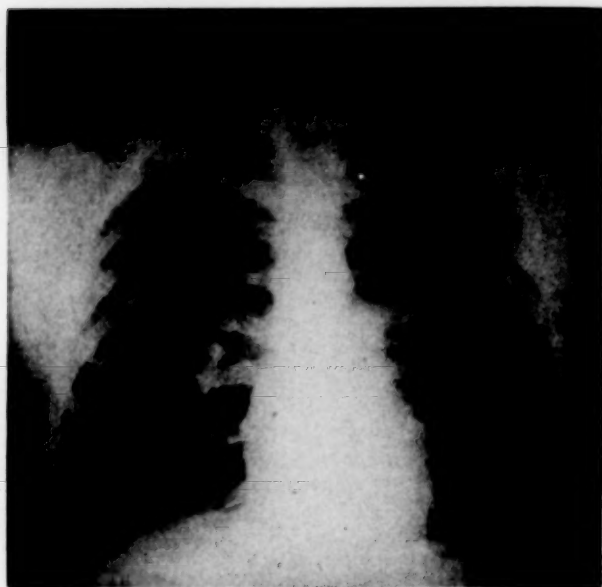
Appearance of lungs of Case 4-229 (Fig. 5) on January 12th prior to development of positive x-ray findings.
